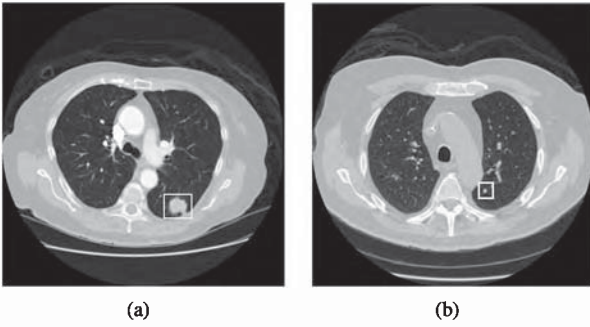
Examples of CT slices containing pulmonary nodules
